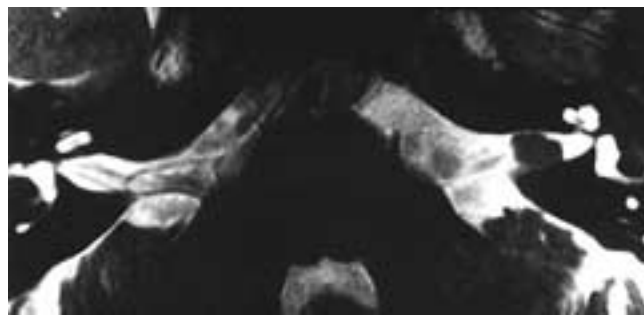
Thin-section (2 mm) T2-weighted image of the IAC. Note the loop of the AICA in the right CPA and the porous acousticus, a segment of the right facial and superior vestibular nerves in the right IAC, and an intracanalicular tumor in the left IAC. (Courtesy of Dr. H.R. Harnsberger.)
